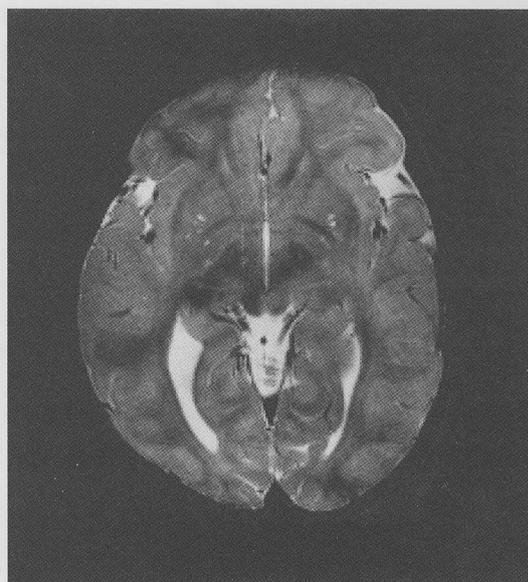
Multiple small bilateral lesions in the basal ganglia, Patient 14. MRI at 1 month (TR 3000/TE 120).
